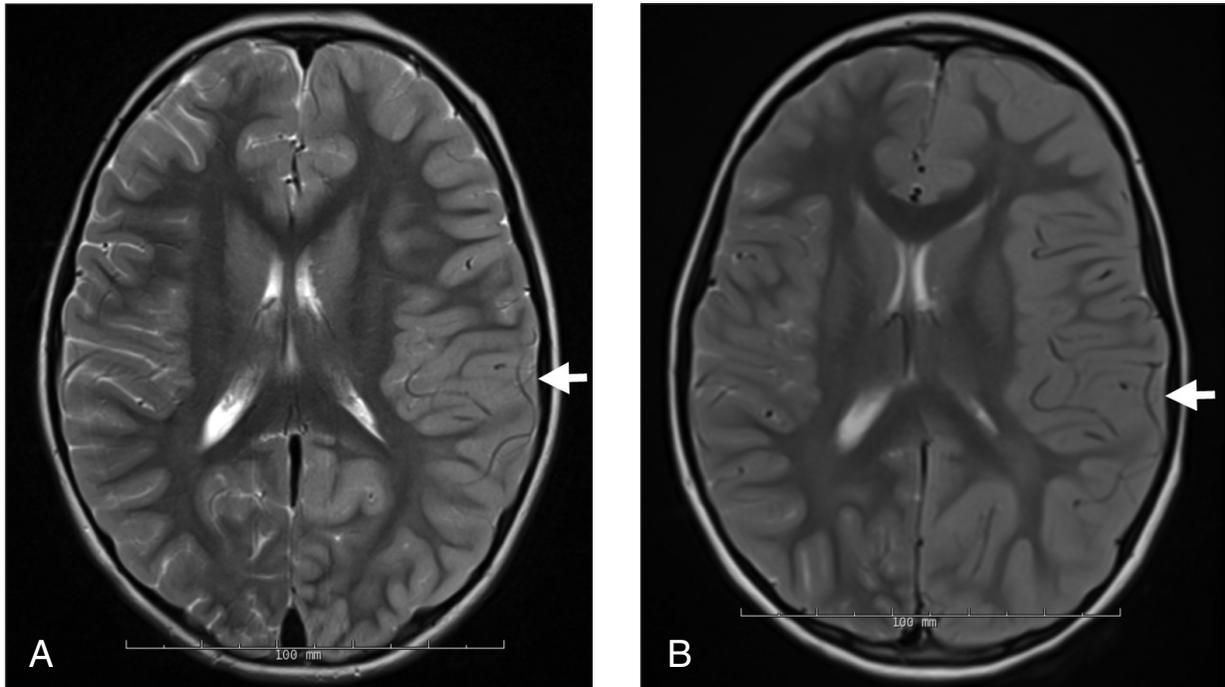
Magnetic resonance imaging (MRI) of the head of the patient at the time of presentation. (A) Axial T2-weighted MRI shows asymmetric diffuse increased T2/FLAIR hyperintensity in the left cerebral hemisphere cortex, with suggestion of mild swelling of the gyri (arrow). (B) Repeat MRI shows interval worsening of the gyral swelling in the left cerebral hemisphere (arrow), with interval increase in mass effect and shift of midline structures.
